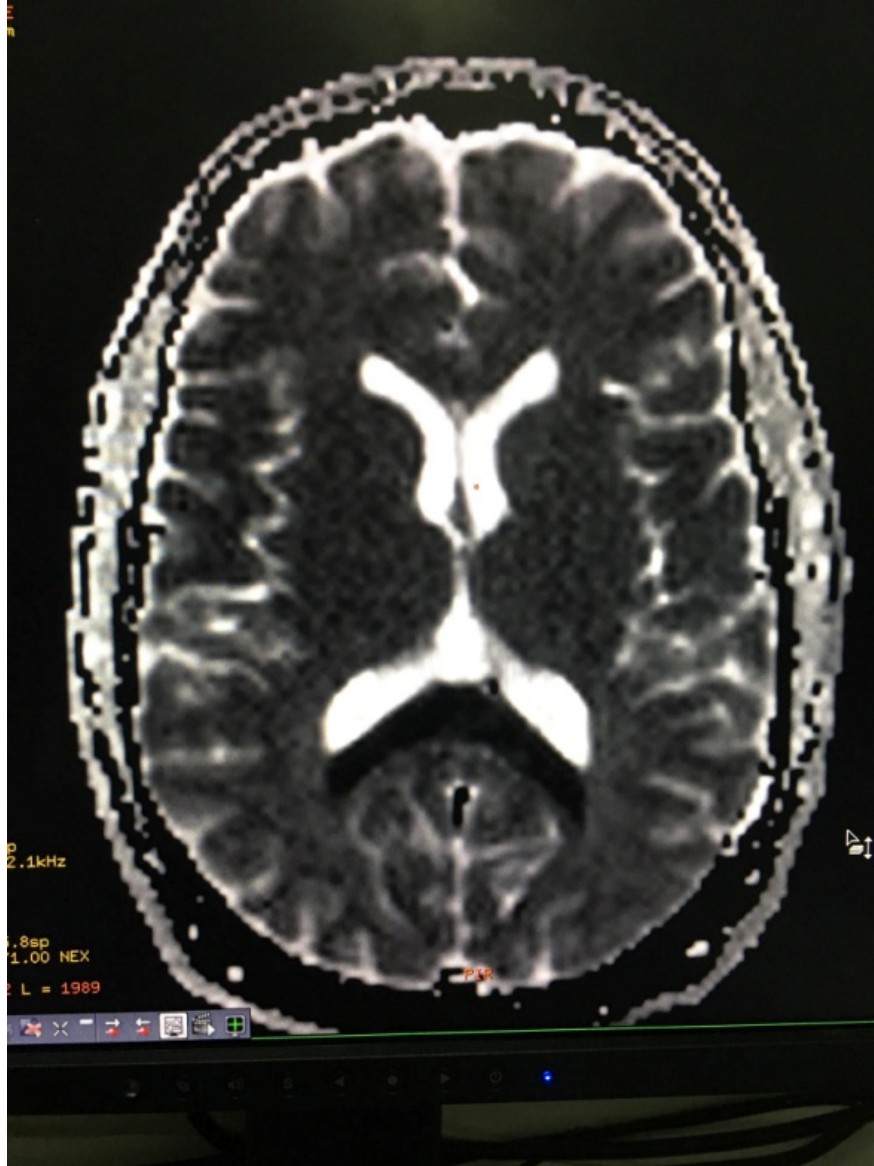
A cerebral angio-MRI was performed showing high signal intensity on T2 weighted images and diffusion weighted images.
